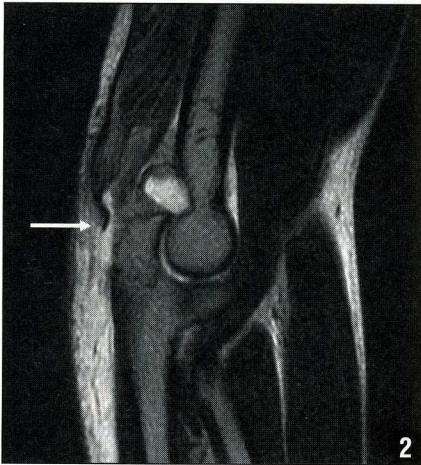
T2-sagittal MRI showing complete avulsion of the triceps tendon at its insertion into the olecranon. The retracted tendon is marked with an arrow (Courtesy of Dr Derek Armfield).
